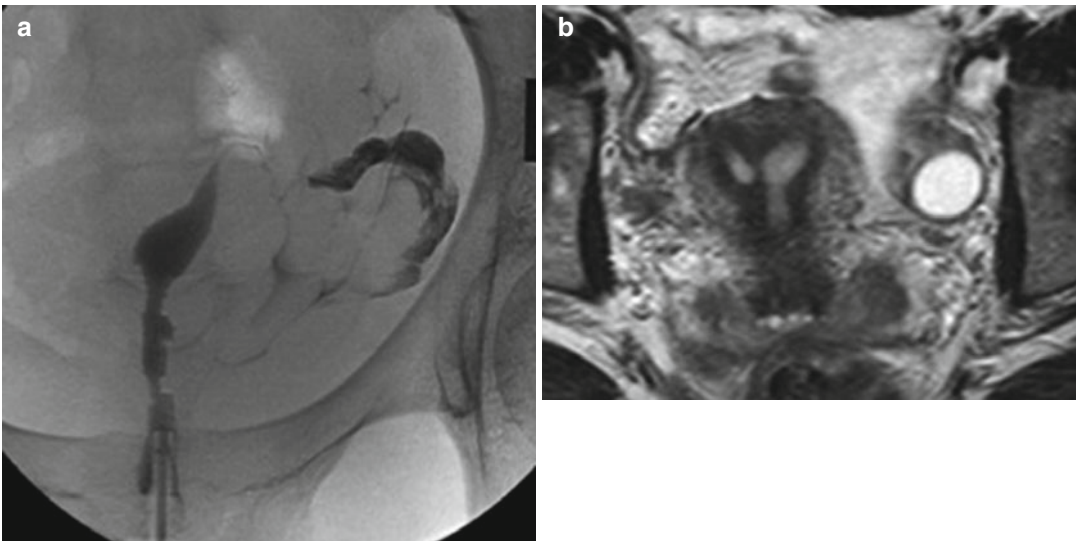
Septate cavity with synechiae mimicking a hemi-uterus. HSG (a) in a woman who had suffered recurrent miscarriage suggests a left hemi uterus, MRI
